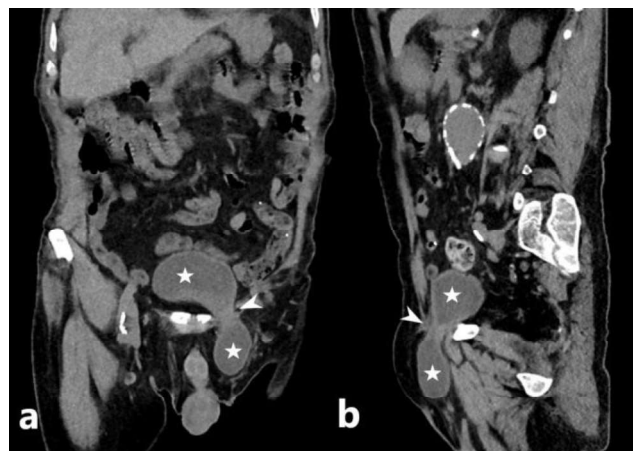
Left inguinal bladder herniation and dumbbell sign in coronal (a) and sagittal (b) CT images. Bladder parts (stars) and trapped part in inguinal canal (arrowhead)
